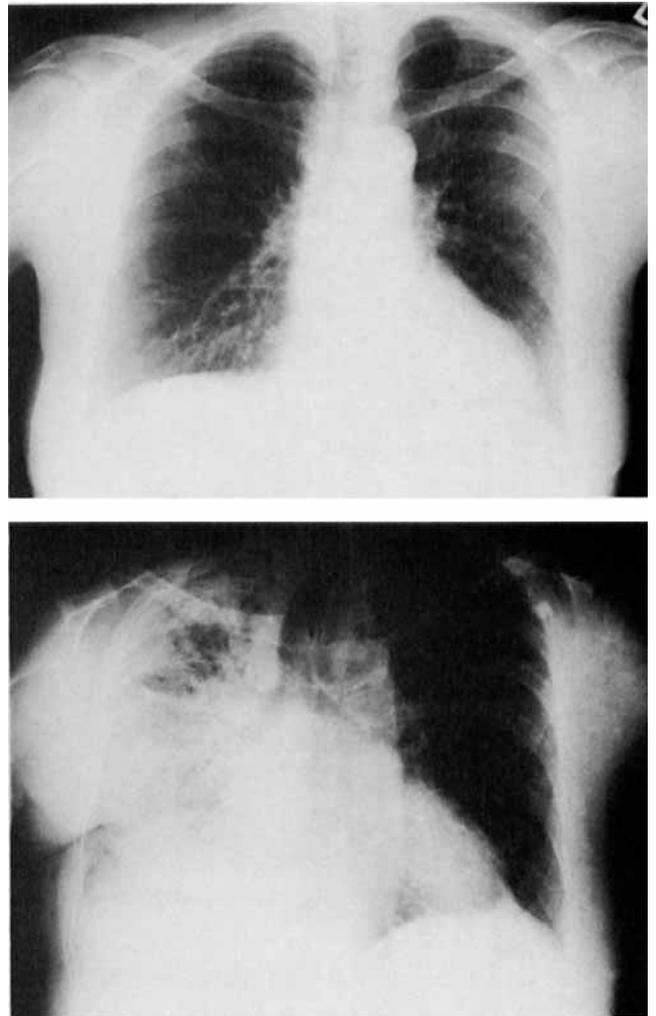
Chest x-ray before radiotherapy (A, top) and 1 week before death (B, bottom).
